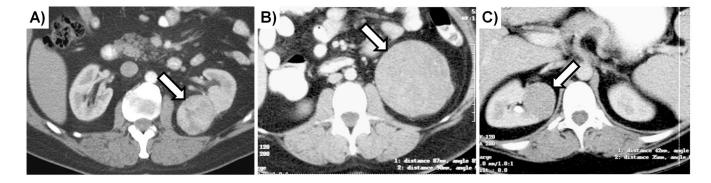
CT Imaging of Cowden/*PTEN* Syndrome Associated RCC (CS-RCC)
